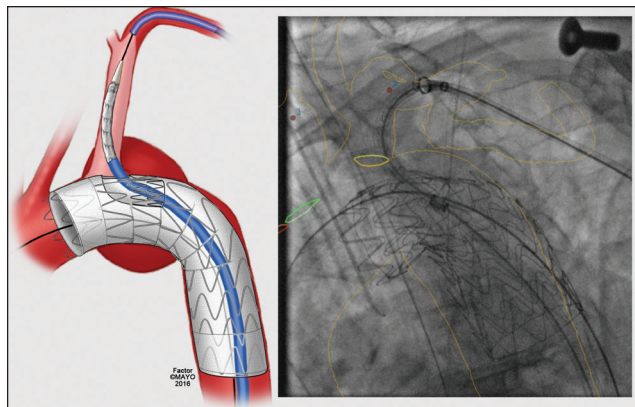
Computed tomography angiography fusion imaging shows vessel outline and origins of the left subclavian (yellow ring) and common carotid arteries (green ring) during deployment of the GORE® TAG® Thoracic Branch Endoprosthesis* to treat distal aortic arch aneurysm. Avoiding repeat angiography markedly reduces contrast use. Used with permission of Mayo Foundation for Medical Education and Research. All rights reserved.
